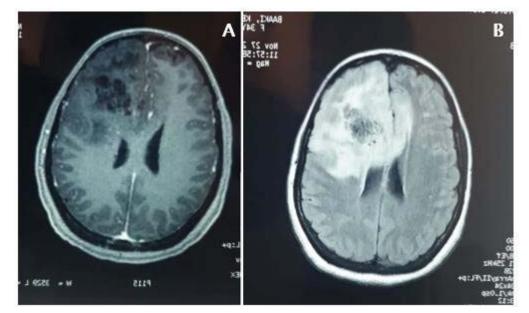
MRI appearance of a high-grade glial tumor in injected T1-weighted sequence (A), and in FLAIR sequence (B). [17]
